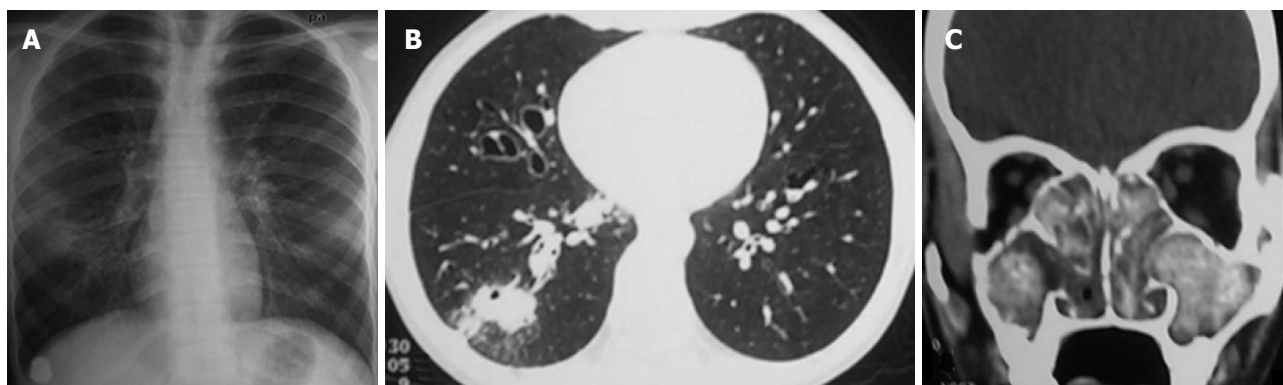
A 12-year-old girl with allergic bronchopulmonary aspergillosis. Frontal chest radiograph (A) and axial computed tomography (CT) image (B) showing tubular opacities with consolidation in the right lung suggestive of mucocoeles along with cystic bronchiectasis in bilateral lungs. Coronal CT image (C) of the patient showing evidence of bilateral allergic fungal rhinosinusitis.
